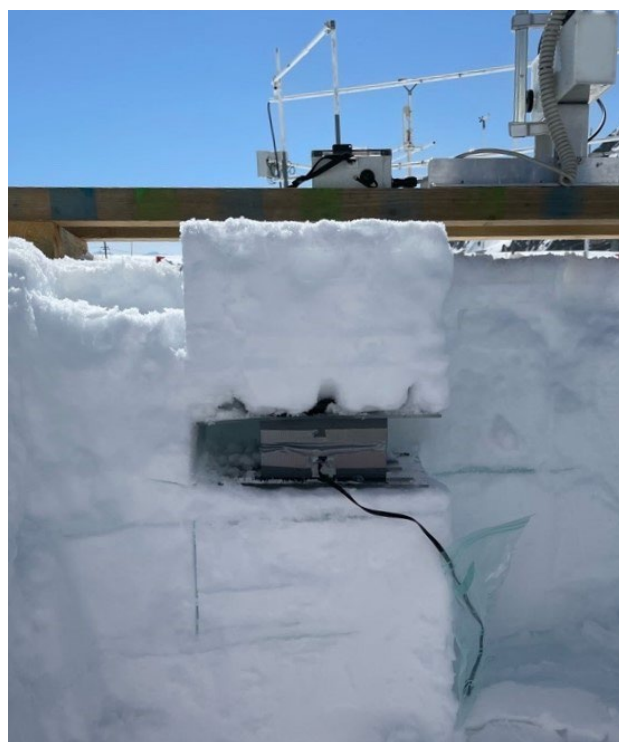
CT block with measurement plate, ready to be loaded. Picture: Weissfluhjoch, March 2022.
